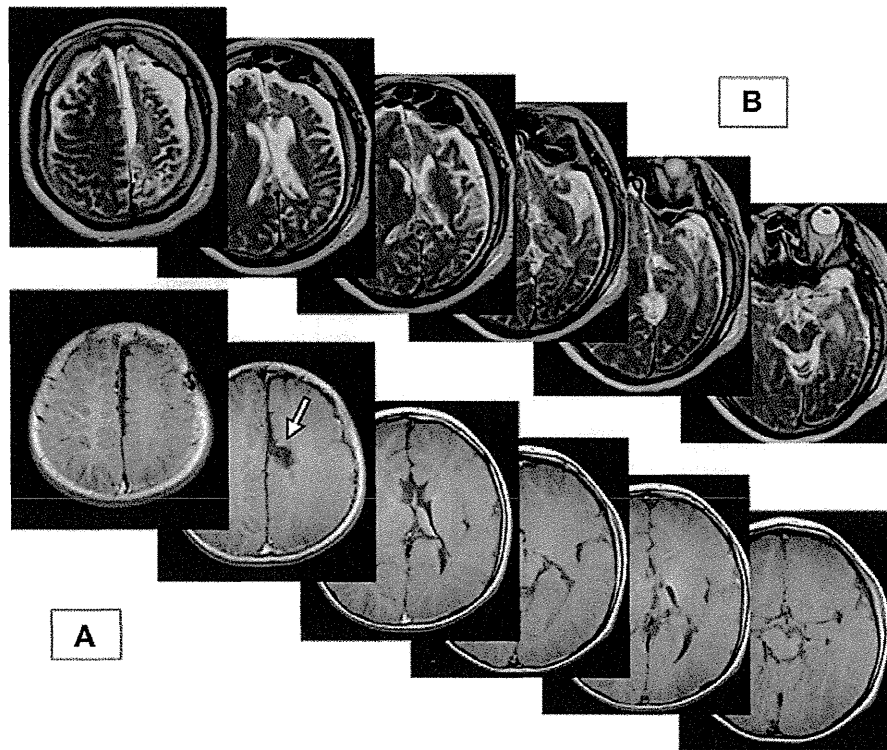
Serial images of postoperative MRI in the representative patients. (A) Two years after surgery in an infant with hemimegalencephaly. (B) Two days after surgery in an adult with hemiatrophy. In both patients, the corpus callosotomy was completely disconnected via an interhemispheric approach and the thalamus was completely disconnected by the minimal cutting plane. In A, a small part of the cingulate gyrus was resected to gain the lateral view.
